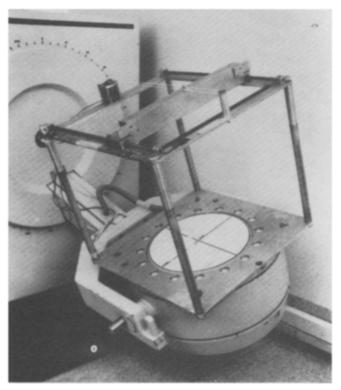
One of first scanning line source devices for transmission correction in SPECT. (From Tan P, Bailey DL, Meikle SR, Eberl S, Fulton RR, Hutton BF. J Nucl Med 1993;34:1752-60.)
